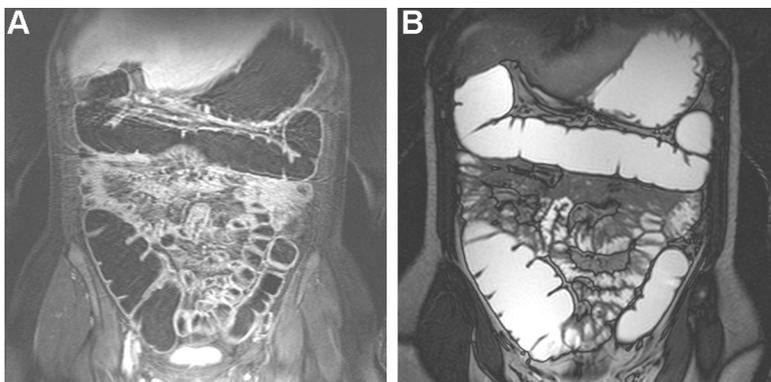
A 54-year-old female patient undergoing magnetic resonance colonography (MRC). Image quality of the contrast-enhanced T1-weighted VIBE dataset (dark lumen MRC, A) is slightly inferior to the True FISP-based bright-lumen MRC (B) as a result of motion artifacts in the transverse colon.
